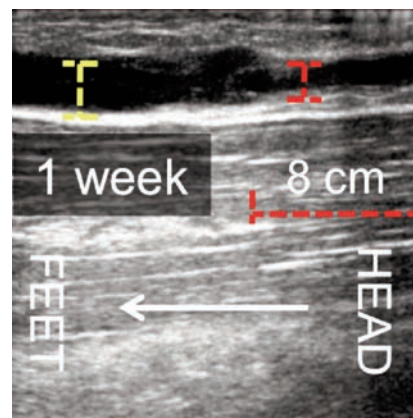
Case B wall thickening at the 1 week follow up echo-color-Doppler. The finding was extended from the distal great saphenous vein shrinkage for 8 cm downward.
